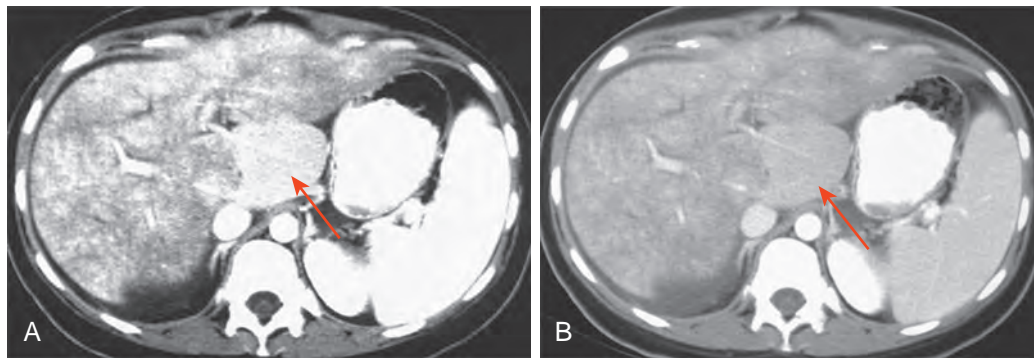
Budd-Chiari syndrome: flip-flop pattern on MR. The classic CT flip-flop pattern of hepatic contrast enhancement is shown in this patient with Budd-Chiari syndrome. A. Contrast-enhanced MR image of the liver shows rapid enhancement (arrow) of the unobstructed central portion of the liver with a delayed peripheral hepatogram. B. Delayed image shows that the central, unobstructed portion of the liver (arrow) has washed out, while the periphery is slowly accreting contrast material.
